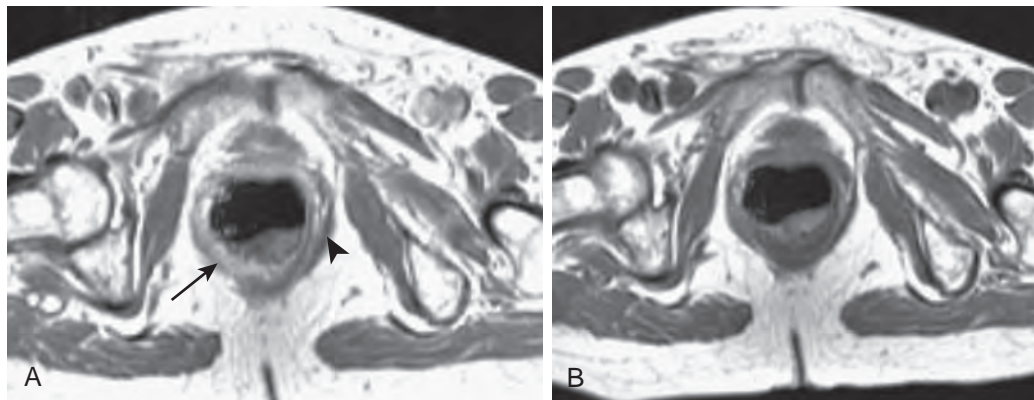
MRI scans of rectal adenocarcinoma with extension into the levator ani muscles (T3N0M0; Dukes' stage B2). A. Axial T1-weighted spin-echo image after gadolinium demonstrates thickening and enhancement in posterior and right lateral rectal wall administration, with direct invasion of tumor into levator ani. This suggested extension by increased signal intensity of muscle in invaded area (arrow). Compare this appearance to the normal left levator ani, which has low signal intensity (arrowhead). B. Tumor invasion into the levator ani is difficult to diagnose on T1-weighted sequence without gadolinium.
